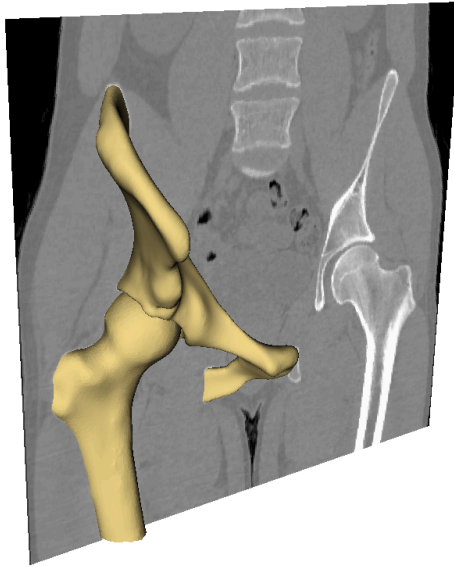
Final Processed Bone Exterior Surfaces Embedded in a Frontal CT Slice
